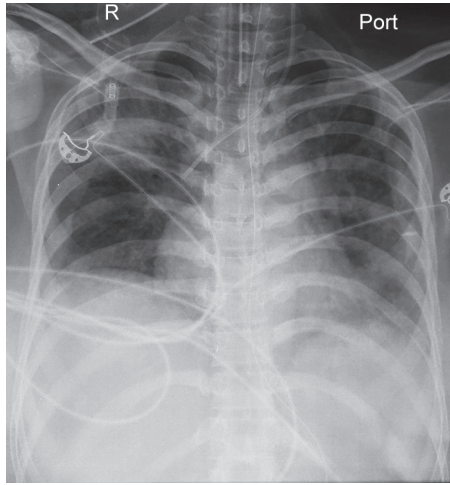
Chest X-ray on day 7 showing significant resolution of the airspace opacities
